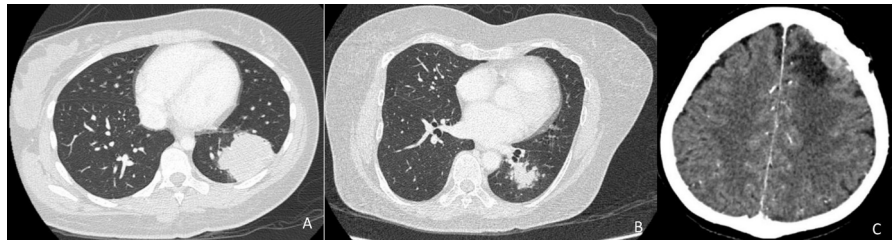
(A) CT thorax reveals a heterogeneously enhancing mass located in the posterobasal segment of the left lower lobe. (B) CT thorax shows an irregular, heterogeneously enhancing lesion in the posterobasal segment of the left lower lobe, with an air bronchogram present within it. (C) CT brain demonstrates an irregular hypodense mass in the left high frontal region, accompanied by extensive white matter oedema in the left frontal lobe.
